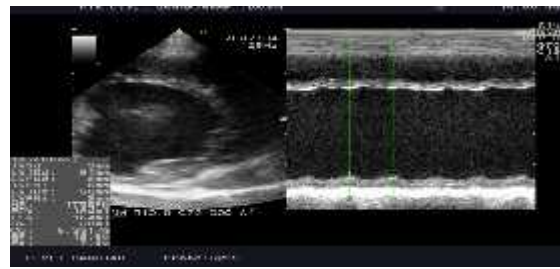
Right parasternal short axis view showing FS: 7.6 percent
